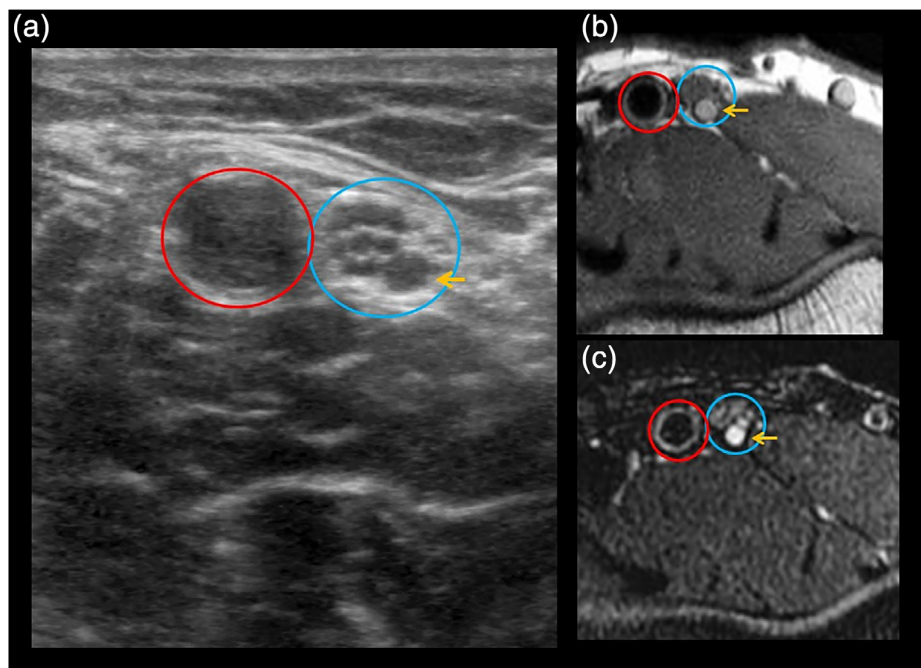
Parsonage-Turner syndrome: Grayscale ultrasound (a) and axial proton density (b) and T2-weighted Dixon fat suppression (c) magnetic resonance images demonstrate focal enlargement and decreased echogenicity/signal hyperintensity of the posteriorly positioned fascicular bundle (yellow arrow) of the median nerve (blue oval) (corresponding to the anterior interosseous nerve) immediately above the level of the medial epicondyle. Note that adjacent brachial artery (red oval). [Color figure can be viewed at wileyonlinelibrary.com]
